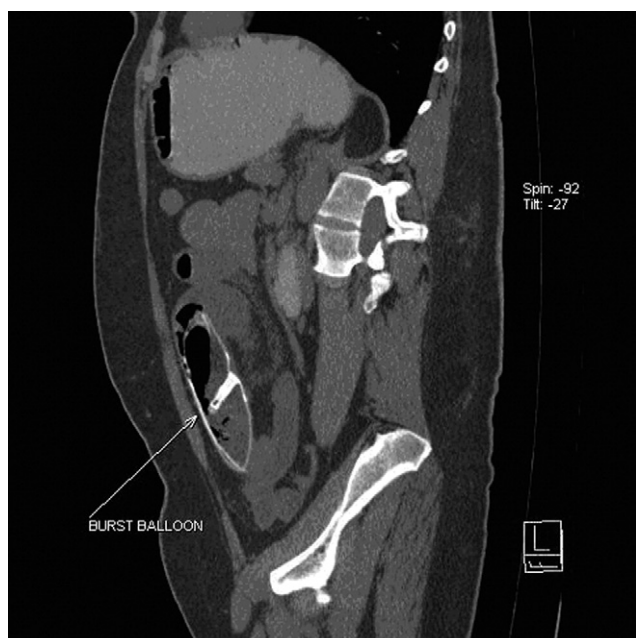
Computed tomography scan showing balloon obstruction.
